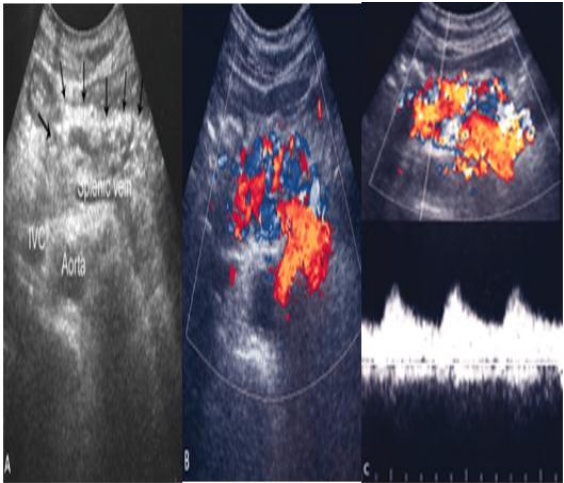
Arteriovenous malformation involving the body of the pancreas in a 55-year-old man. A, on gray scale ultrasonography, multiple tubular anechoic structures are shown in and around the pancreas (arrows). IVC indicates inferior vena cava. B, Color Doppler ultrasonography shows a large amount of color signals filled in and around the pancreas in a mosaic pattern. C, Spectral Doppler ultrasonography mainly shows arterial waveforms with relatively high velocity.
